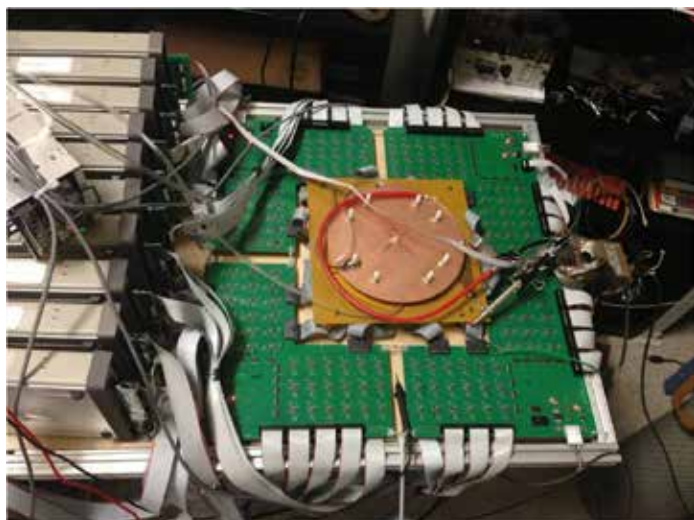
Prototype Micromegas-based system for proton radiography.
